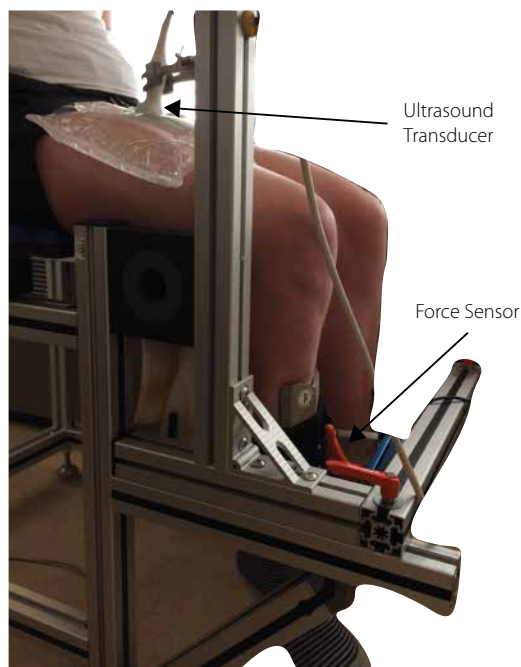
Experimental set-up for collecting in vivo ultrasound data from the subject's right leg during isometric contraction of the quadriceps muscles. The exerted force was recorded using a force sensor at the lower leg. 3D ultrasound data were acquired at the center of the quadriceps muscle.
